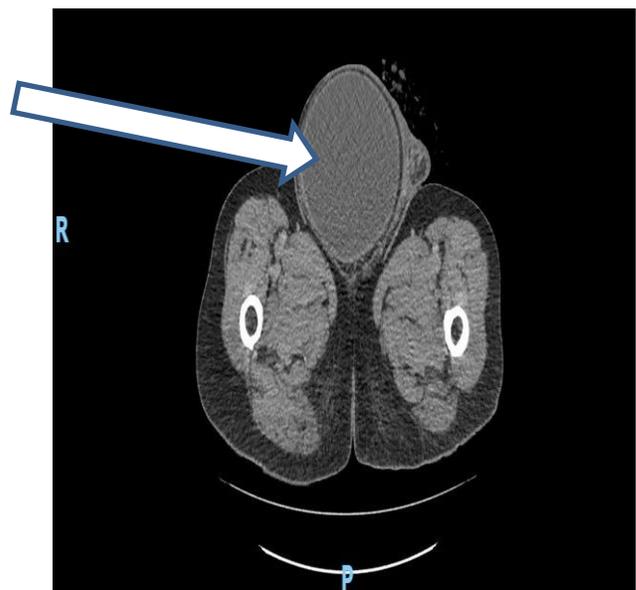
CT scan showing completely herniated bladder into the right hemiscrotum.
